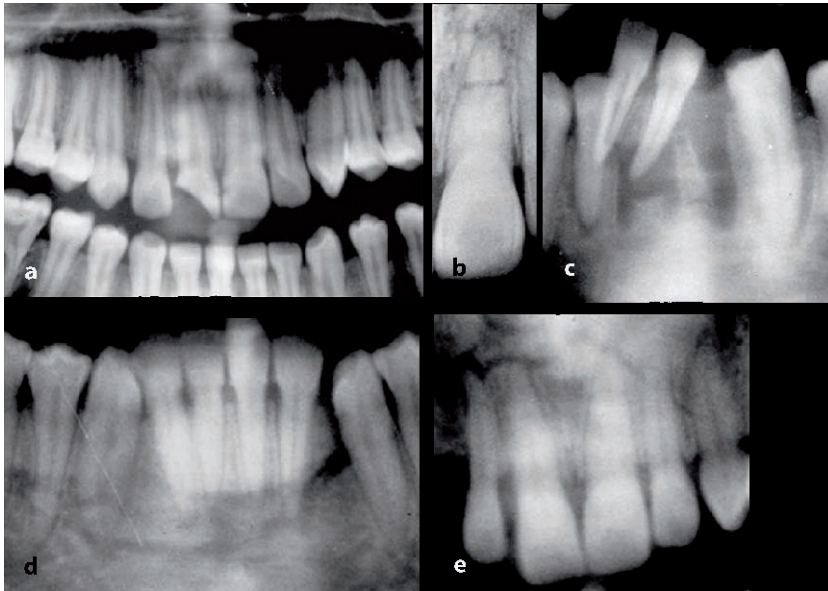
Traumatic dental injuries. a Detail of panoramic radiograph showing fracture of crown of right maxillary central incisor tooth. b Periapical radiograph demonstrating root fracture to left maxillary central incisor tooth. c Panoramic detail of luxation of mandibular anterior teeth. d Panoramic detail of mandibular alveolar fracture. e Panoramic detail of maxillary alveolar fracture
